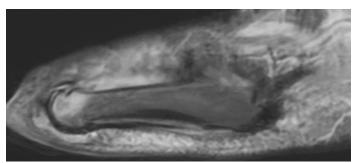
Sagittal reconstruction, T2 weighted MRI image of the left foot showing increased signal intensity within the distal portion of the fifth metatarsal neck and head consistent with osteomyelitis.
